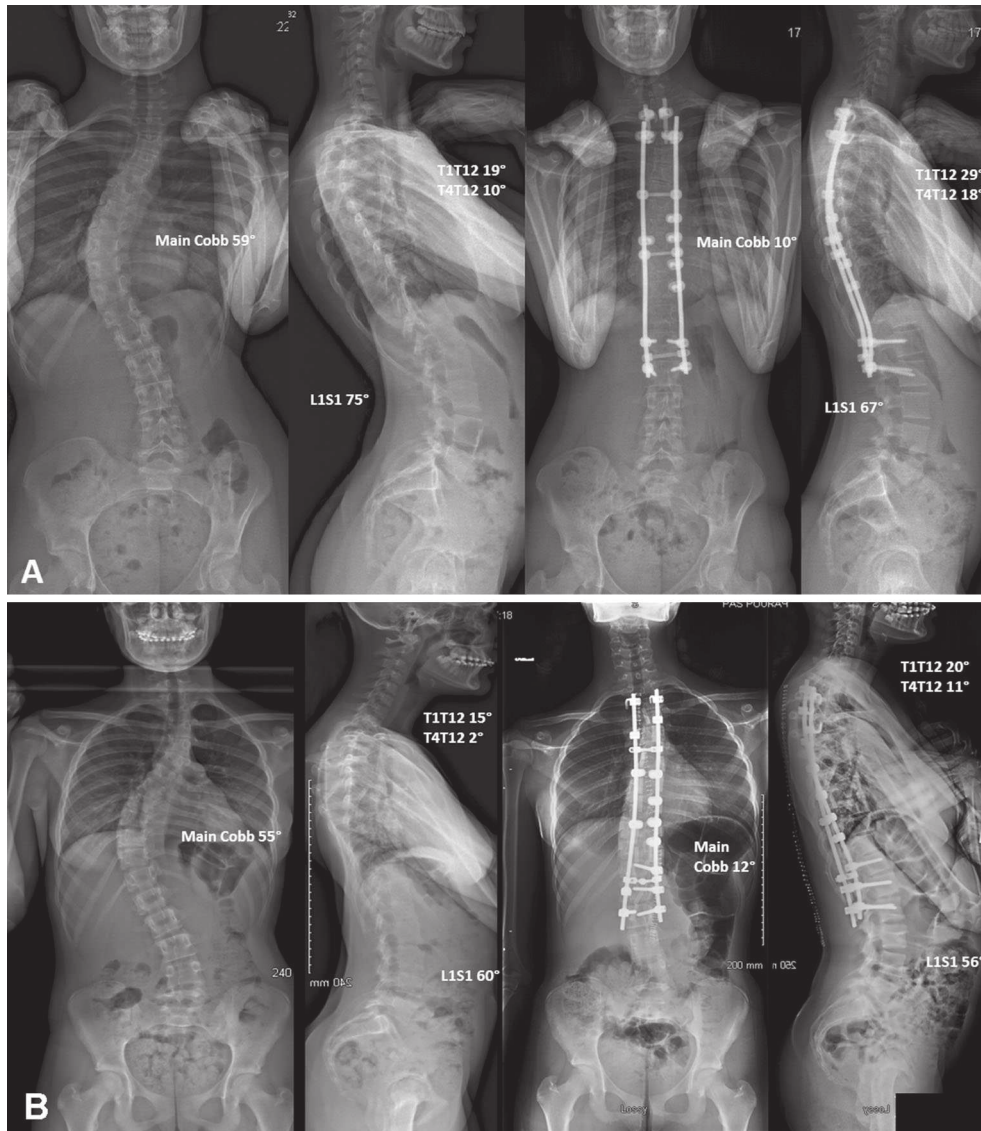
Preoperative and postoperative radiographs of AIS patients corrected by posteromedial translation using hybrid constructs with CoCr rods (a) or Ti rods (b)
